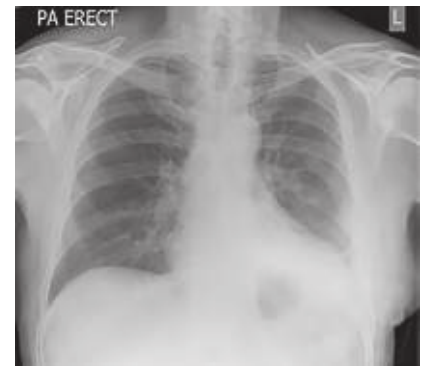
Left diaphragmatic paralysis. Chest x-ray displaying elevation of the left hemidiaphragm with displacement of bowels into the left hemithorax. (Reproduced with permission from Elshafie G, Acosta J, Aliverti A, et al. Chest wall mechanics before and after diaphragm plication. *J Cardiothorac Surg.* 2016;11:25. Published 2016 Feb 2. doi:10.1186/s13019-016-0419-x.)
